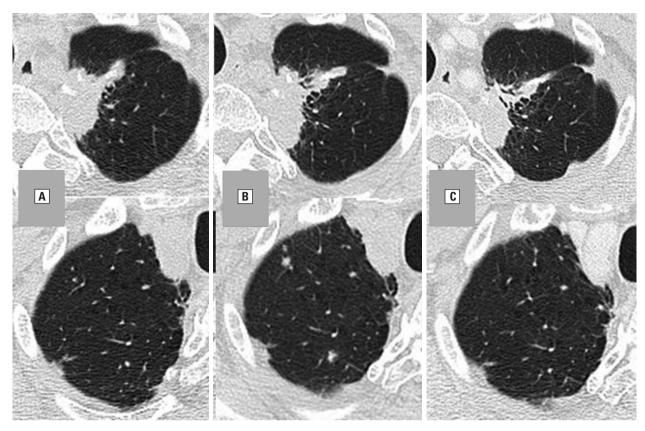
Regrowth of the left mediastinal lesion was found in chest CT scan 10 months after the initiation of the fourth-line chemotherapy (A). Enlargement of the left mediastinal lesion and pulmonary metastases were found in chest CT scan taken at 4 weeks after the initiation of the rechallenge therapy (B). The left mediastinal lesion was shrunk and pulmonary metastases decreased in size or disappeared in chest CT scan taken at 12 weeks after the initiation of the rechallenge therapy (C)
